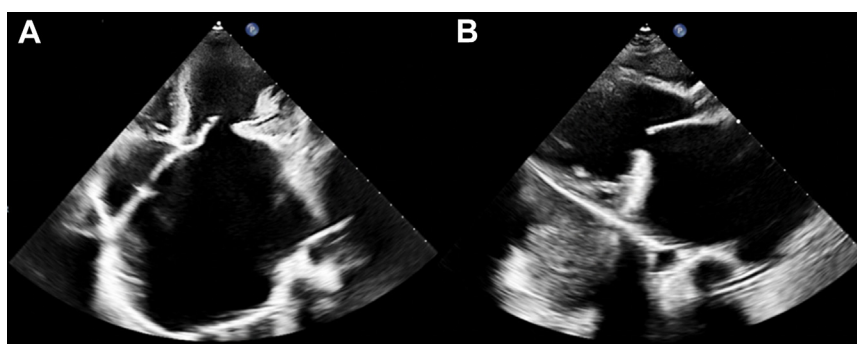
Transthoracic echocardiogram. Apical 4-chamber (A) and parasternal long views (B) showing 9-cm giant left atrium from anteroposterior measurement.
